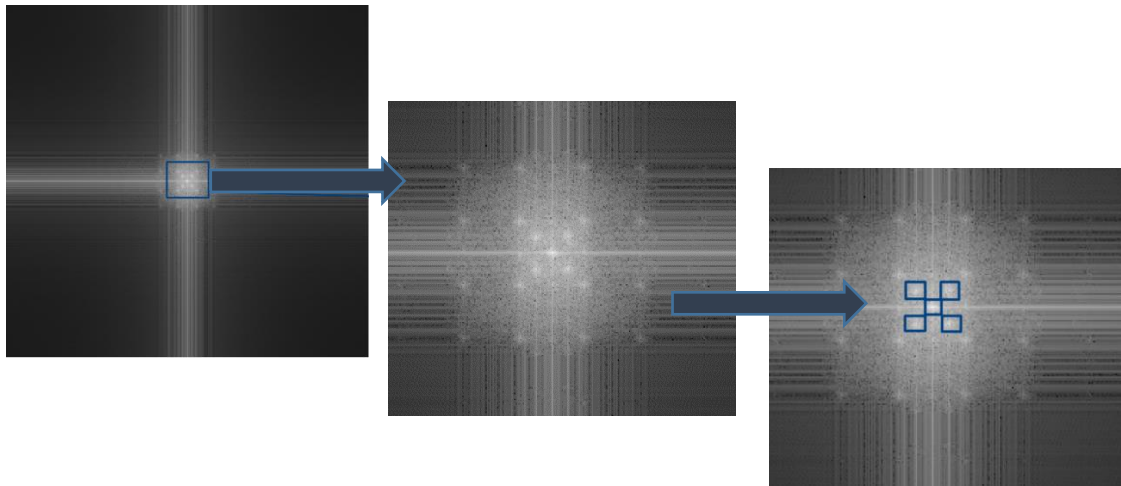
Fourier Transform of the SPAMM MRI image represented in Figure 3.2 (left) and a closer visualization of the peaks (image in the middle). The two sets of orthogonal tagging patterns of the image originate a central peak and four harmonic peaks: two peaks in 45° and 225° due to one orthogonal direction and other two in 135° and 315° due to the other orthogonal direction of tagging (at right). [Images from this study]
